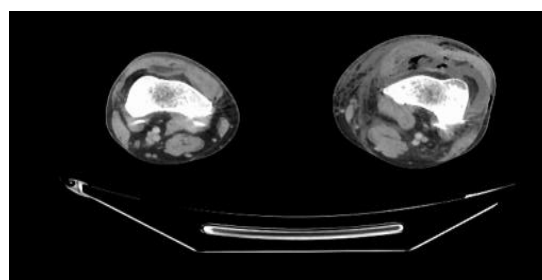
CT images - cross section with free gas: Thigh.
